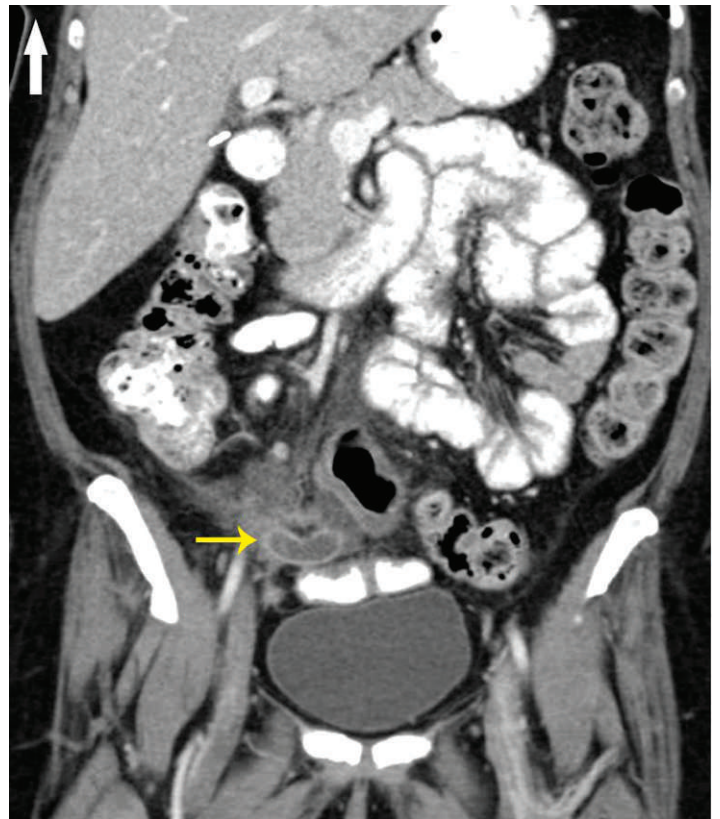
Contrast-enhanced abdominal computed tomography of the abdomen performed in the emergency department showing a dilated appendix with enhancing wall and surrounding fat stranding (arrow) suggestive of acute appendicitis.
